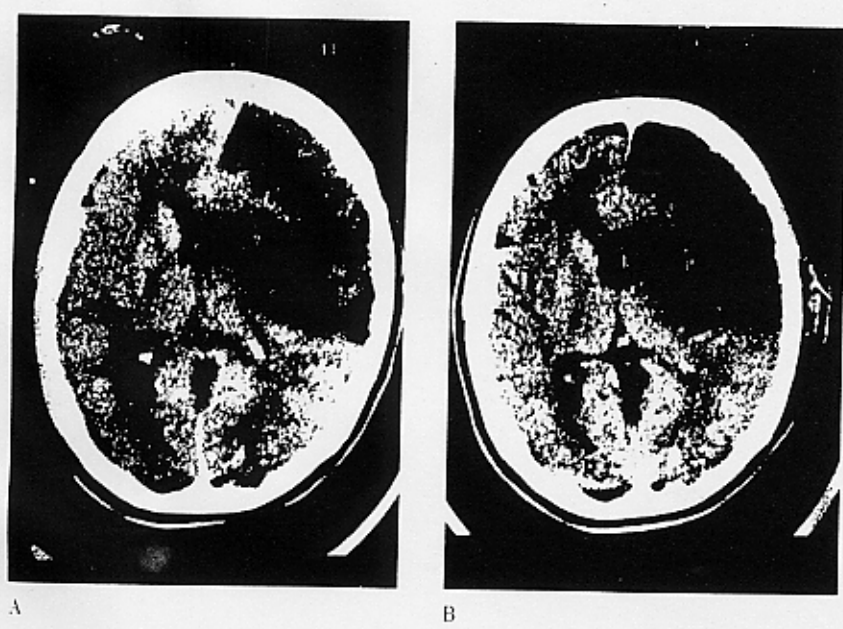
(A) CT at the septum pellucidum level in a 35-year-old woman with left-hemispheric MCA infarction. Note compression of the lateral ventricle and severe midline shift (5 mm). (B) After 12 hours of hypothermic therapy, there was a reduction of mass effect and only slight midline shift (2 mm).
